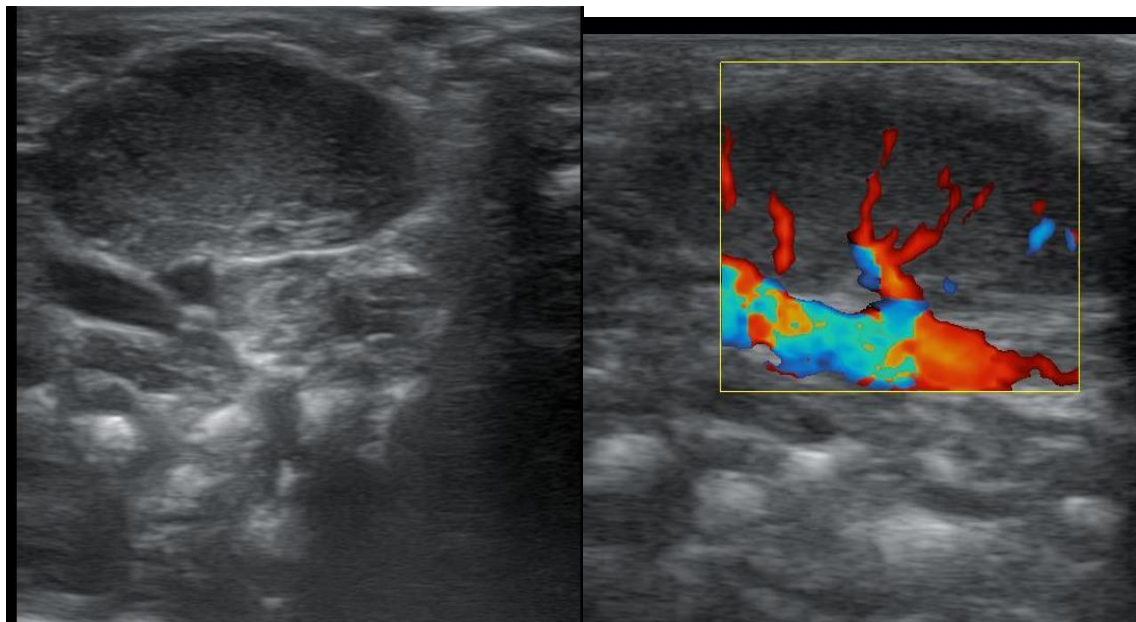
Ultrasound showing fusiform thickening of left sternocleidomastoid muscle
